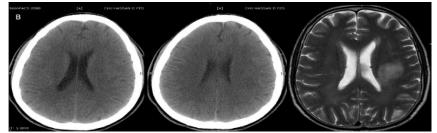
43 years old women, with right hemiparesis. Negative CT examination with corresponding T2 WI showing a wellcircumscribed lesion (confirmed PCSNL).
